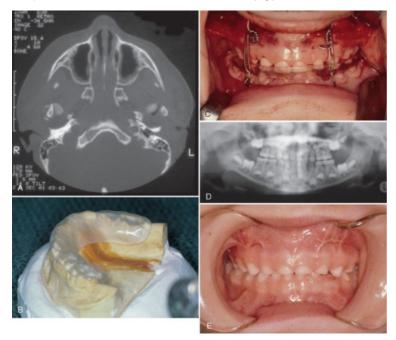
A 5-year-old patient was an urrestrained passenger in a motor vehicle accident. A, Non-contrast-enhanced axial computed tomography scan demonstrating multiple intracapsular fractures of the bilateral condyles. Additional lower cuts also revealed a right symphysis fracture through the developing permanent carine tooth bud. B, After nasally intubating the patient in the operating room, dental molds were taken and store cars to each here, was sectioned at the displaced fracture line of the right parasymphysis and reduced relative to the maxillary dentition C, An acrylic splint was inner flabticated to index these adjustments. The acrylic splint was inserted after placing bilateral 24-gauge skeletal wires at the pirforms and circum-mandibularly. Care was taken to not pass the right circum-mandibular view within the fracture line of the right netermediate 26-gauge wires were then out and the patient line. D, A pancraine raidorgraph taken 2 weeks after removal of the skeletal suspension wires shows good maintenance of the entire dentition and no developing open bite. Both condyles are beginning to re-form. E, Occlusion 6 months after surgery showing vertical overlap and good interdigitation.
